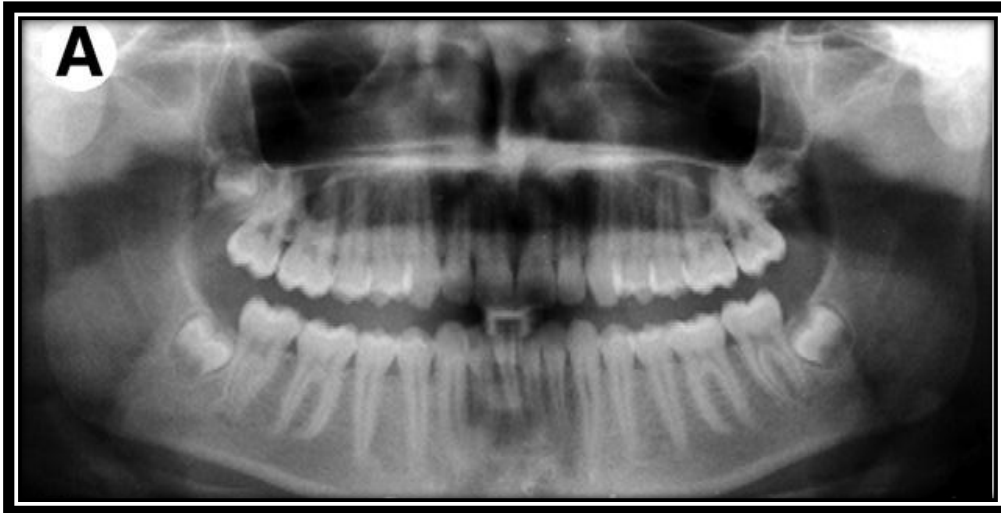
Orthopantomograph demonstrating four impacted third molars that are mirror images of each other
